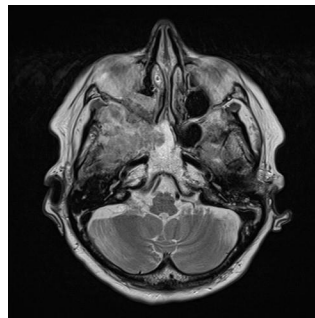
Brain MRI showed a 62 mm × 37 mm large tumor that infiltrated the right orbit, eroded the skull base, protruded into the middle cranial fossa suppressing the brain, and infiltrating the sphenoid and maxillary sinus. MRI: Magnetic resonance imaging.
